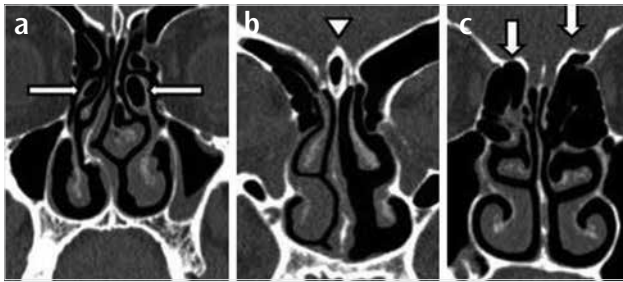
a-c. Coronal CT images of different patients showing, pneumatization of bilateral uncinate processes (arrows) (a), pneumatization of the crista galli (arrow head) (b), asymmetry of the height of the ethmoid roofs (arrows) (c)
